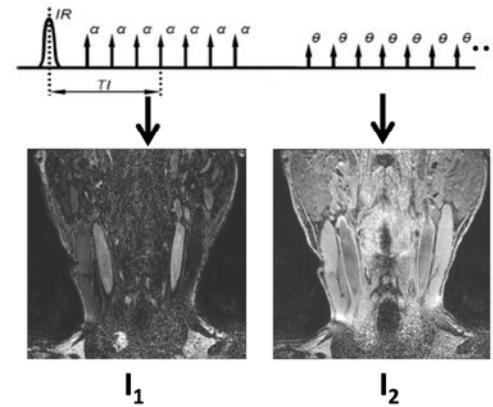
Sequence is based on the SNAP method [2] with a highly T1-weighted $I_1(x, y)$ acquired after a slab-selective inversion with linear encoding and flip angle α . The acquisition is repeated with a small flip angle θ after signal recovery to acquire the PD-weighted $I_2(x, y)$
